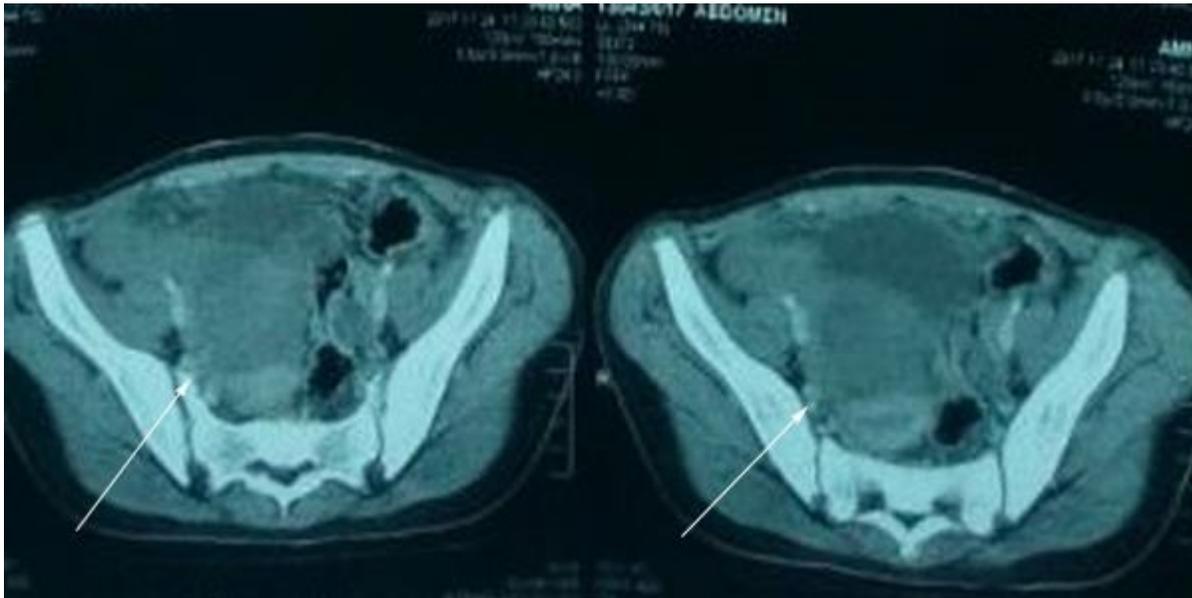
Computed tomography scan of pelvis (Axial view) showing complex cystic lesion with hyperdensity
